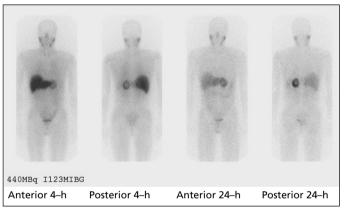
(a) Computed tomography scan showing a left-sided phaeochromocytoma. (b) Radio-iodine-labelled MIBG scans in the same patient: anterior and posterior views 4 hours and 24 hours after injection. There is reduced uptake in the middle of the tumour due to necrosis.
